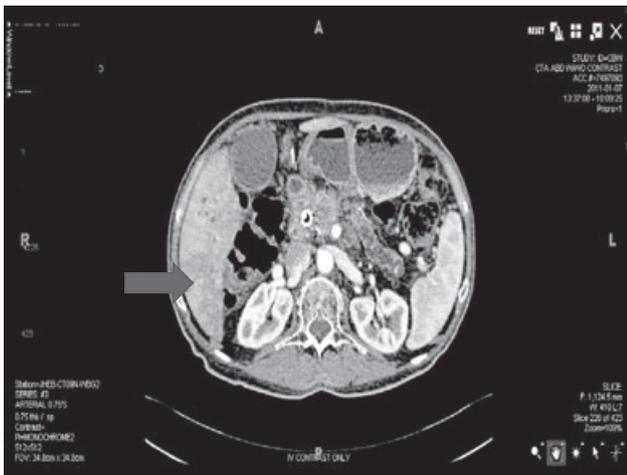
Abdominal CT in the same 64 year-old male showing metastatic lesions present in liver.
